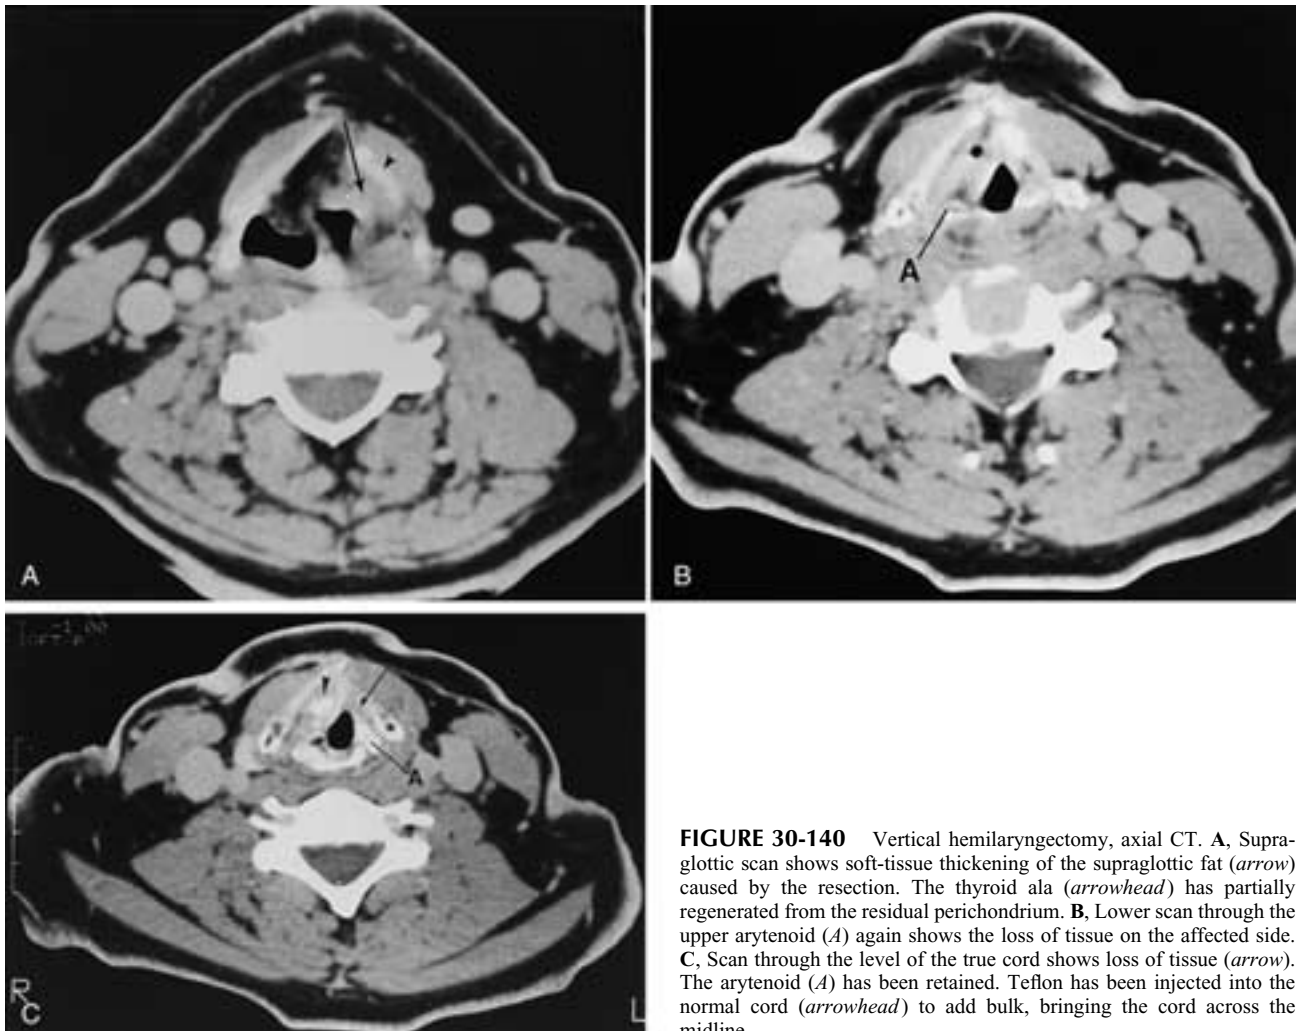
Vertical hemilaryngectomy, axial CT. A, Supraglottic scan shows soft-tissue thickening of the supraglottic fat (*arrow*) caused by the resection. The thyroid ala (*arrowhead*) has partially regenerated from the residual perichondrium. B, Lower scan through the upper arytenoid (*A*) again shows the loss of tissue on the affected side. C, Scan through the level of the true cord shows loss of tissue (*arrow*). The arytenoid (*A*) has been retained. Teflon has been injected into the normal cord (*arrowhead*) to add bulk, bringing the cord across the midline.
